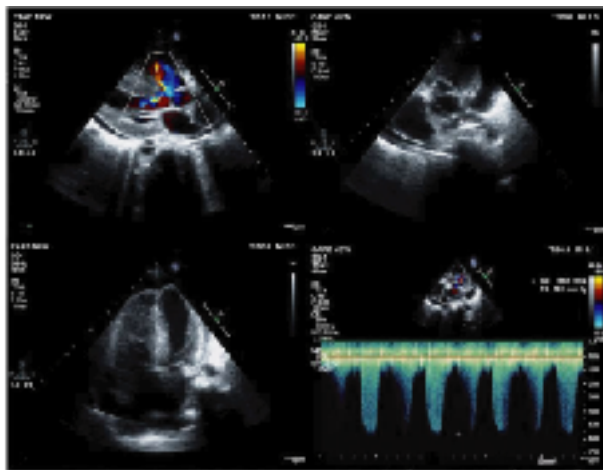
Doppler Echocardiography shows typical findings of TOF- VSD, overriding of aorta, RV outflow tract obstruction & RV hypertrophy.
